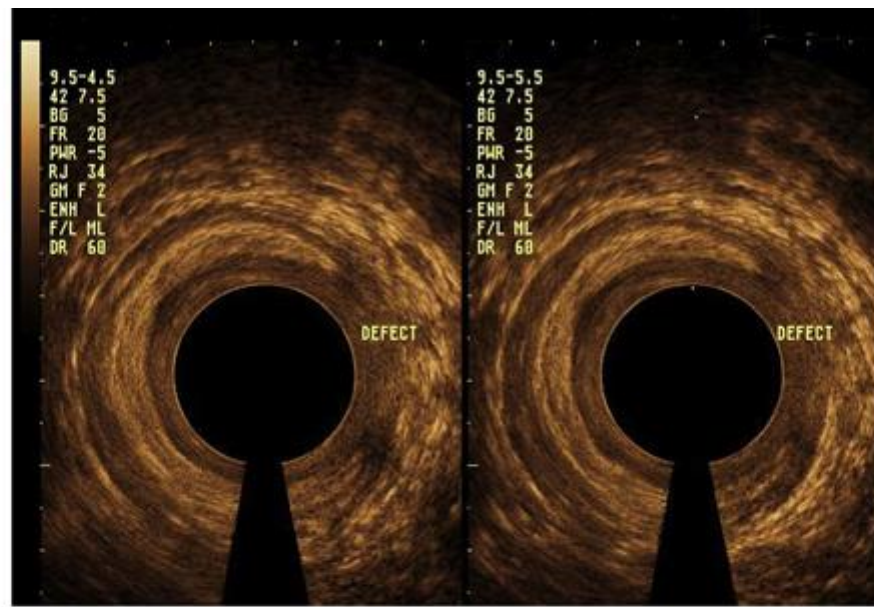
Two-dimensional endoanal ultrasound image of occult external anal sphincter defect.
